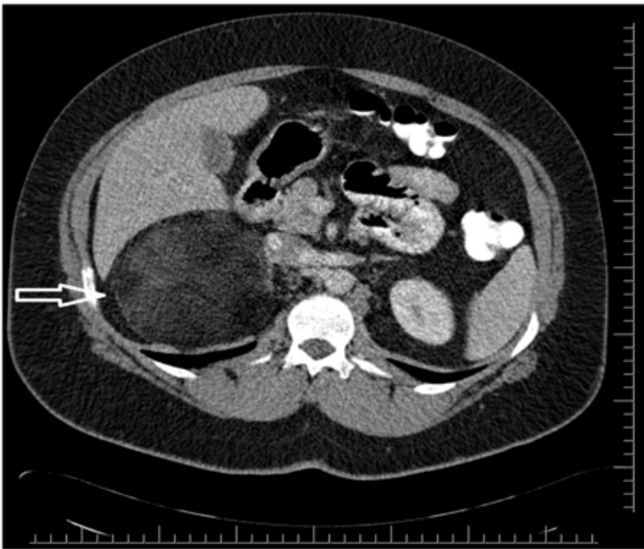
Conformal contour with heterogeneous mass in limited fat densities in the right adrenal gland in computed tomography
